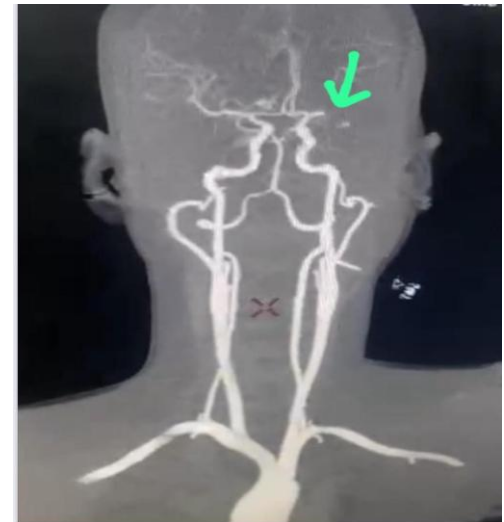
CT angiography –left M1 occlusion
